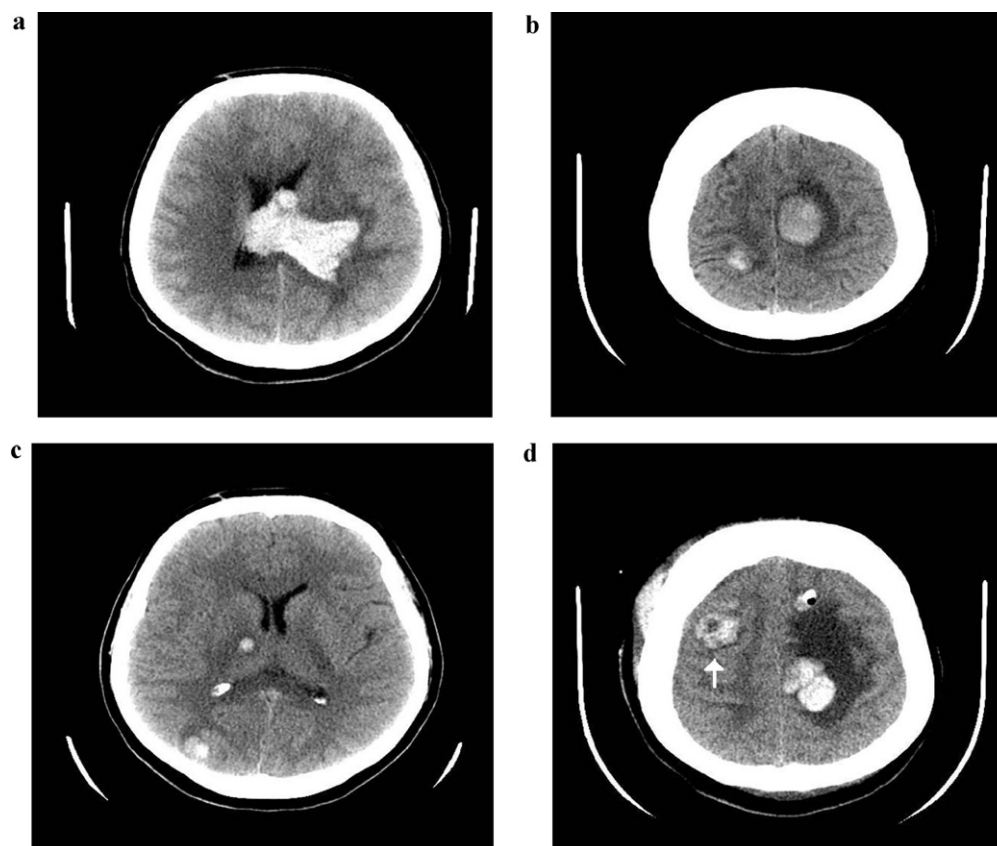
(a) Non-contrast head CT from initial presentation showing thalamic ICH with intraventricular extension of hemorrhage and hydrocephalus. (b) and (c) Non-contrast head CT six months later revealing multifocal hemorrhage in both hemispheres. (d) Right frontal hemorrhage after parenchymal biopsy (white arrow).
